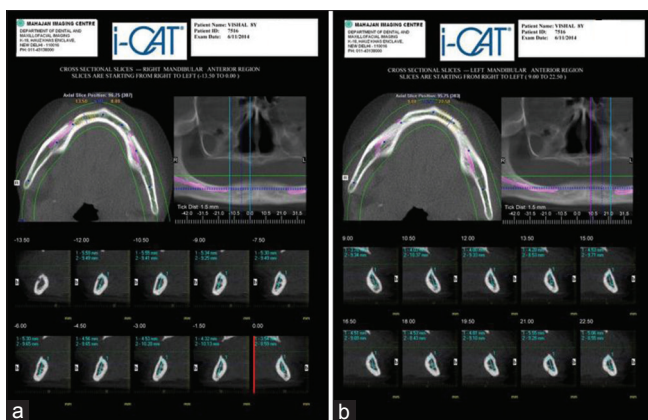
Cone beam computerized tomography right (a) and left, (b) mandible of Case 2
